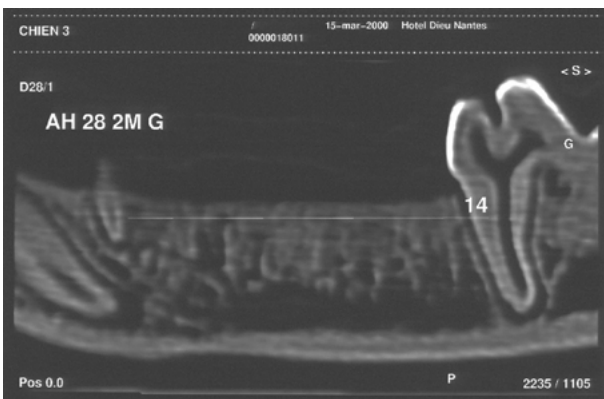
CT image after two months of healing.
